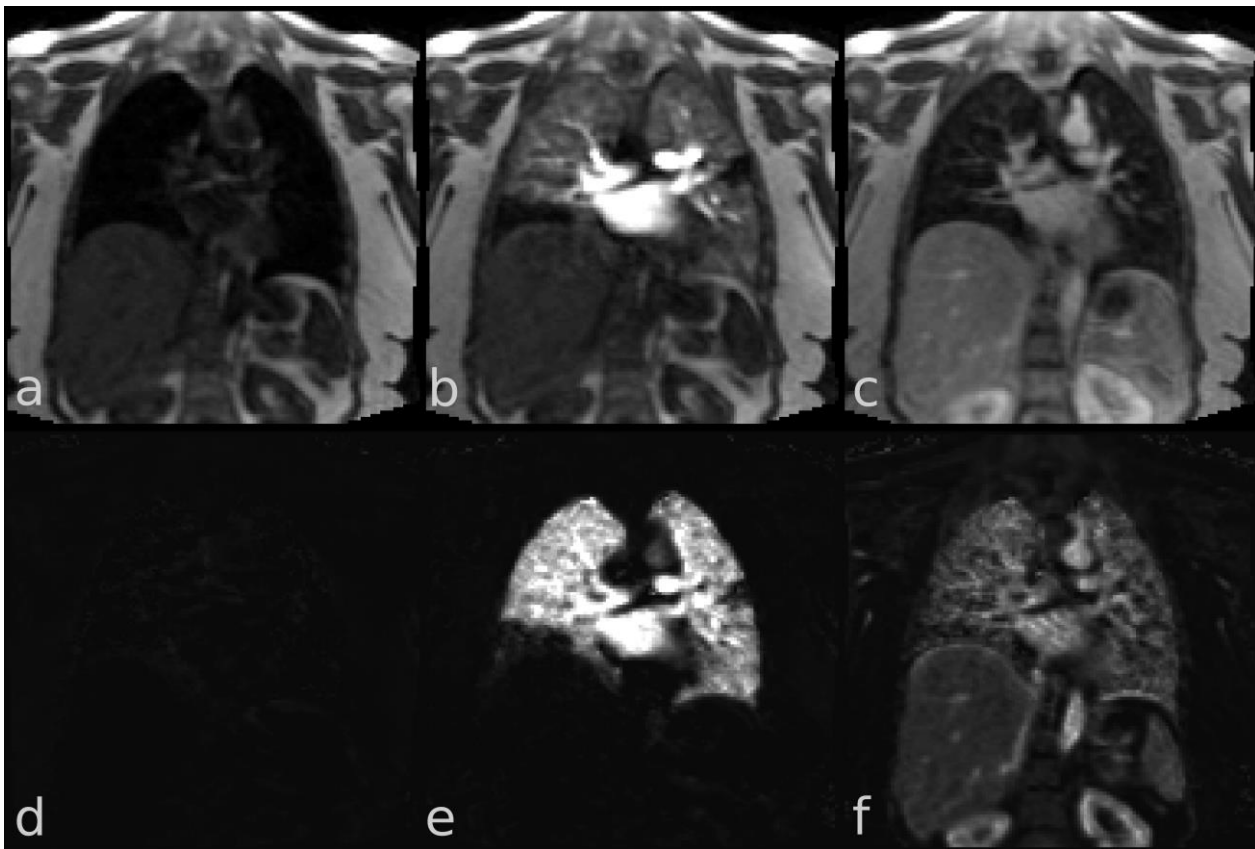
DCE MRI data of a patient with acute pulmonary embolism (subject #2). Top row: unprocessed data before contrast agent arrival (a), at peak pulmonary intensity (b) and in a late phase (c). Bottom row (d-f): Relative enhancement at the same time points. Time frames 1, 9 and 70 were used.
